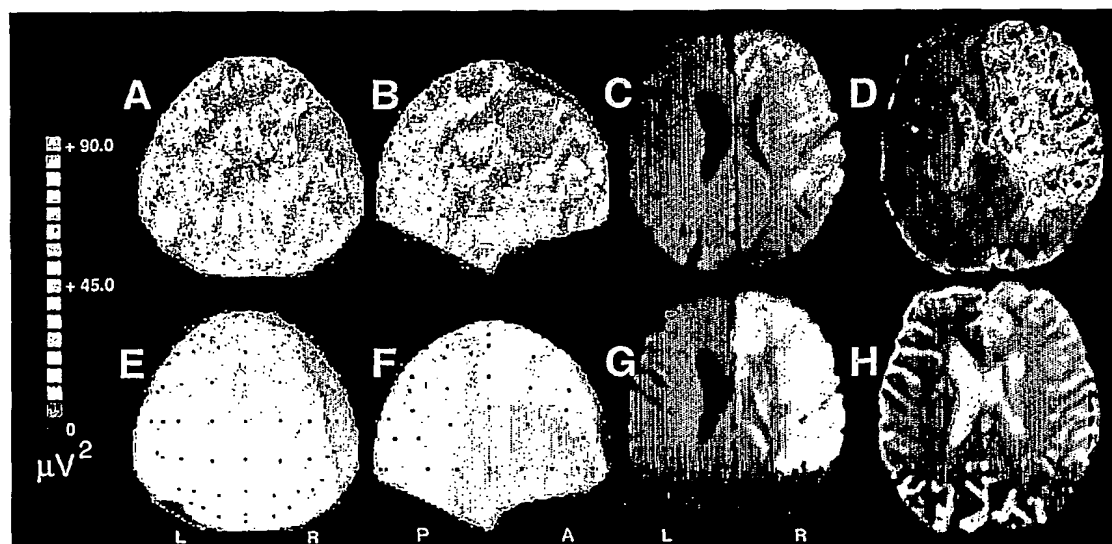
EEG and MRI data from a patient who died at 12 days post-stroke. A and B: Axial and lateral DPM acquired 9 hours after onset of symptoms; C: initial DWI (6 hours); D: initial MTT map; E and F Axial and right lateral DPM at 17 hours; G: 15 hour DWI scan and H: 15 hour T2 MRI.
